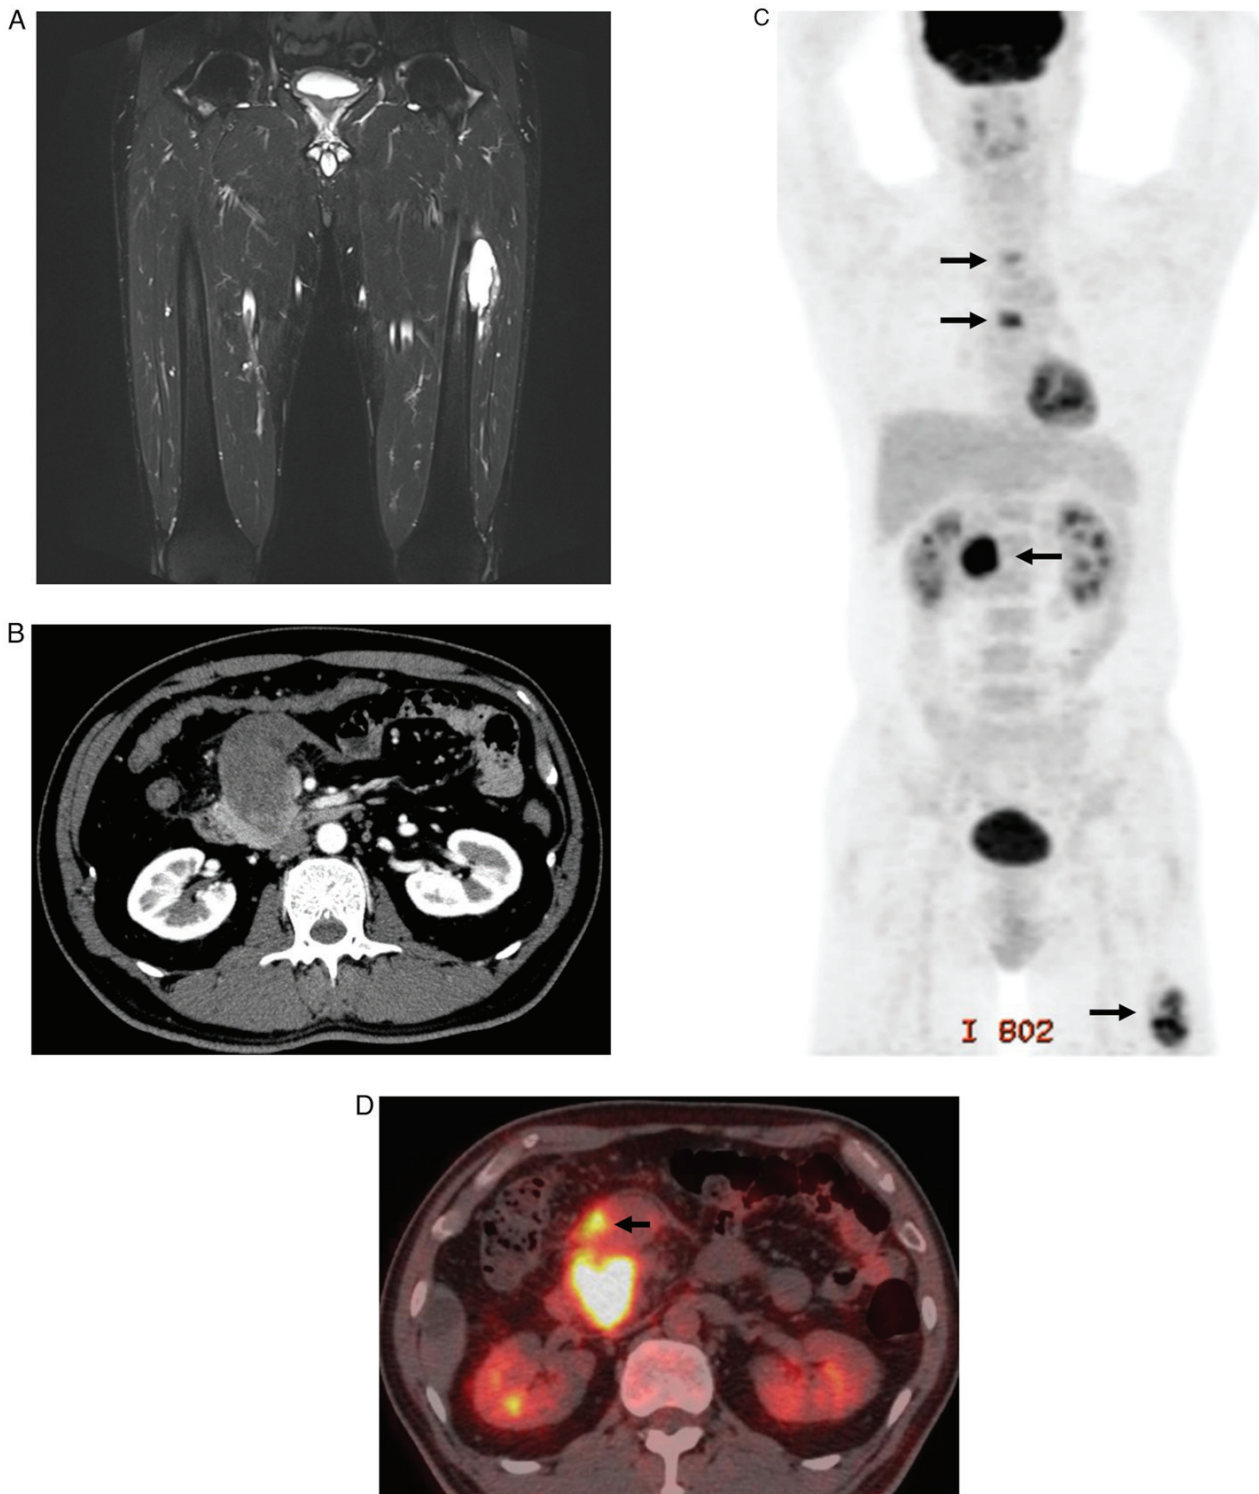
(A) Magnetic resonance imaging (T2-STIR) of the lower legs before treatment. (B) Computed tomography before treatment. (C) Coronal section and (D) axial section of positron emission tomography-computed tomography at the hospital visit. Black arrowheads indicate hypermetabolism.
